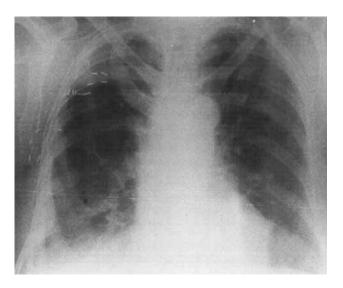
Chest radiograph 3 months after completion of therapy. This remained practically unchanged during subsequent months of follow-up.
